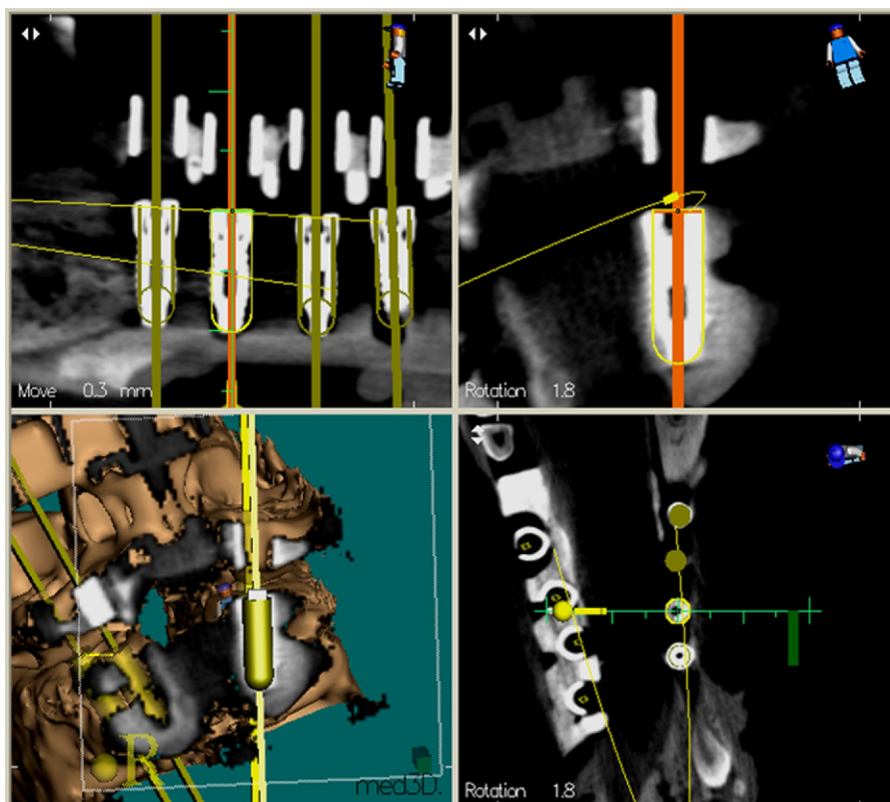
The initial drill plan was positioned on the second CT scan.
